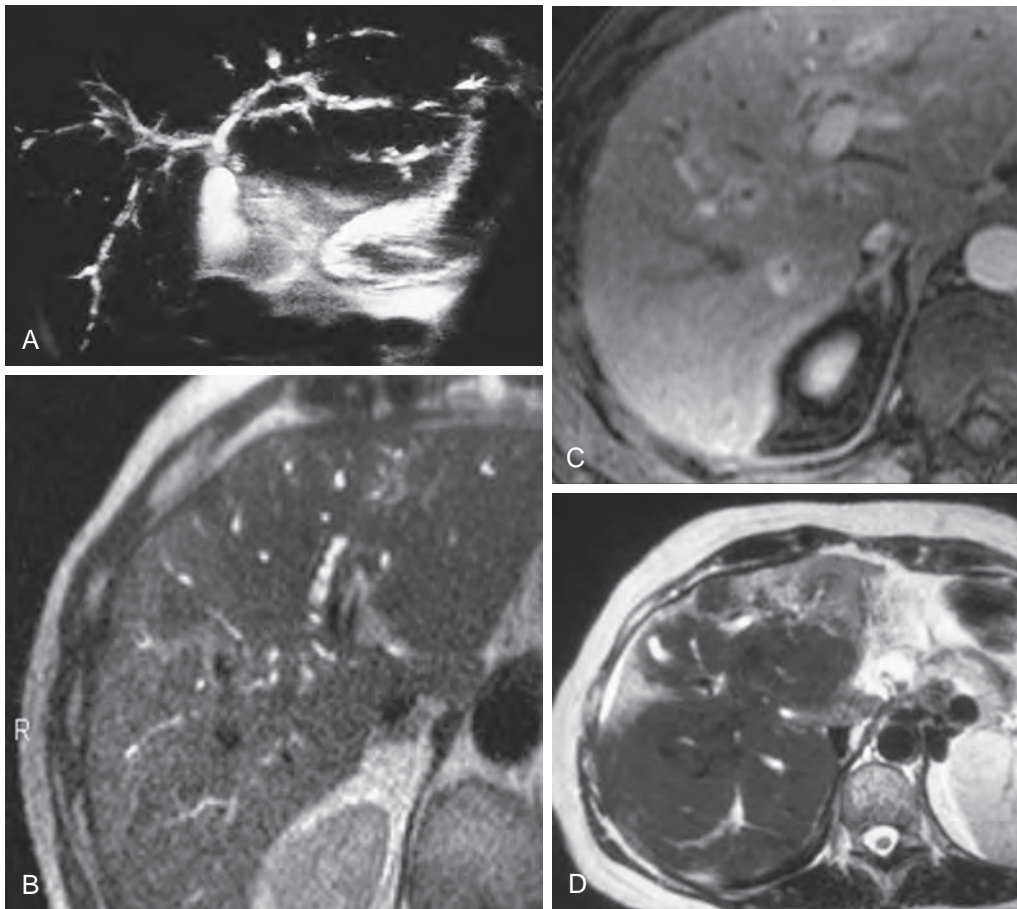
PSC: MR findings. A and B. MR cholangiogram shows characteristic irregular strictures and segmental dilations of the intrahepatic and extrahepatic ducts. C. Abnormal periductal enhancement is seen after contrast enhancement. D. MR image of patient with secondary biliary cirrhosis due to sclerosing cholangitis.
